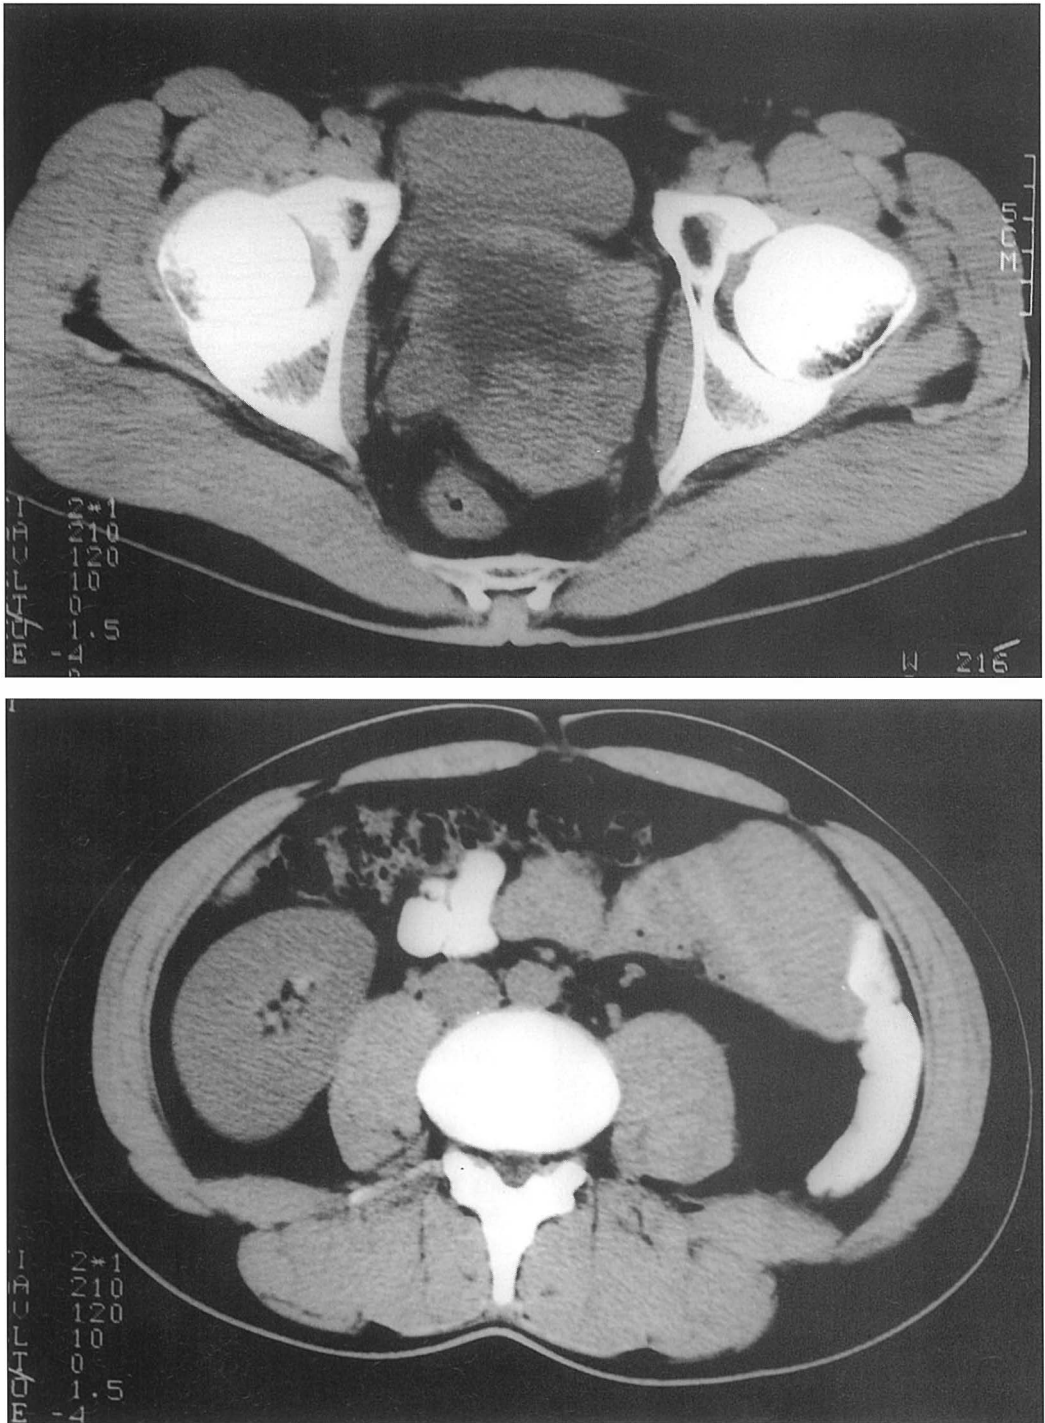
(a) CT visualization of non-homogenous well differentiated tumor in pelvis minor: The core of tumor is hypodense, whereas the periphery is granular soft tissue. (b) Soft tissue tumor.
